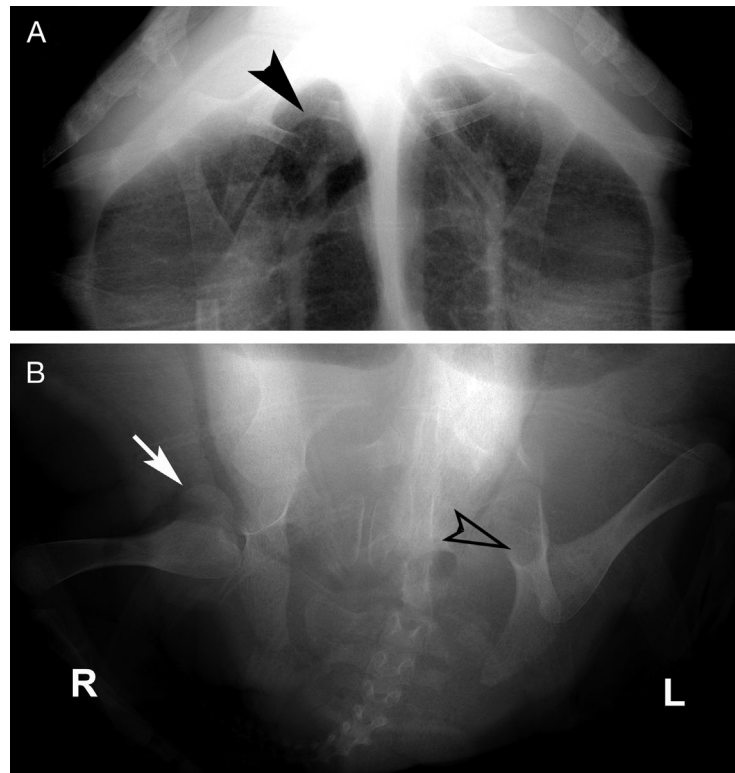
Radiographs of the (A) pectoral and (B) pelvic girdle in dorso-ventral view. Note the (A) fractured right acromion process (black arrowhead), and (B) the lytic left femoral head (empty arrowhead) compared to the normal contralateral (white arrow). R: right body side; L: left body side
